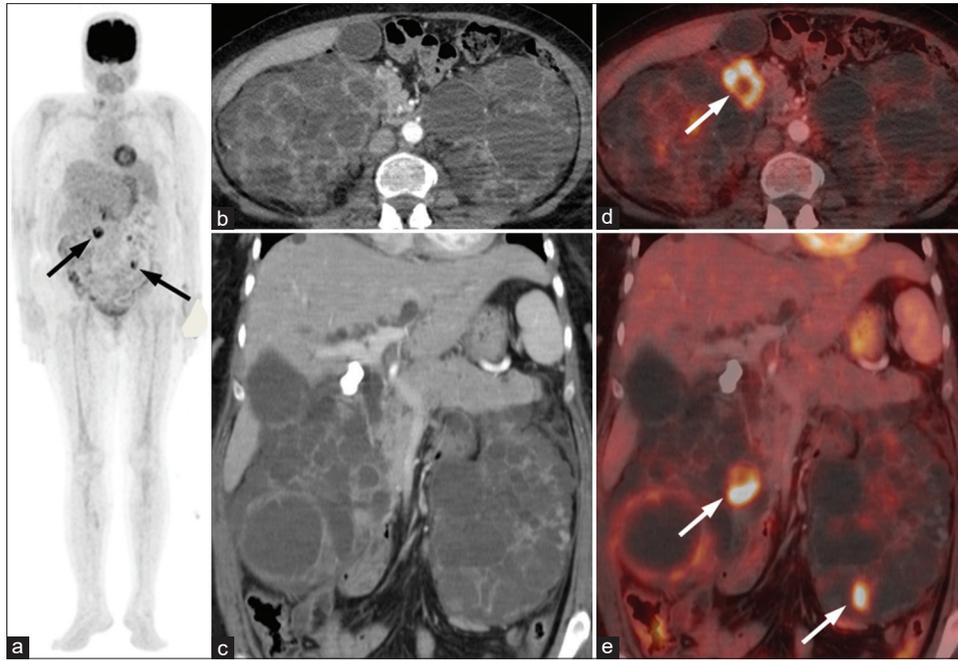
Maximum intensity projection positron emission tomography images (a) showed focal areas of increased ^{18}F -fluorodeoxyglucose uptake in bilateral lumbar regions in abdomen (arrows). Transaxial (b) and coronal (c) contrast-enhanced computed tomography images showed bilateral enlarged kidneys with the renal parenchyma replaced completely with cysts of variable sizes. Fused transaxial (d) and coronal (e) positron emission tomography-computed tomography images revealed increased peripheral fluorodeoxyglucose uptake in two cysts (arrows), one in the right kidney mid polar region (maximum standardized uptake value 8.5) and another in the left kidney lower pole region (maximum standardized uptake value 5.1)
